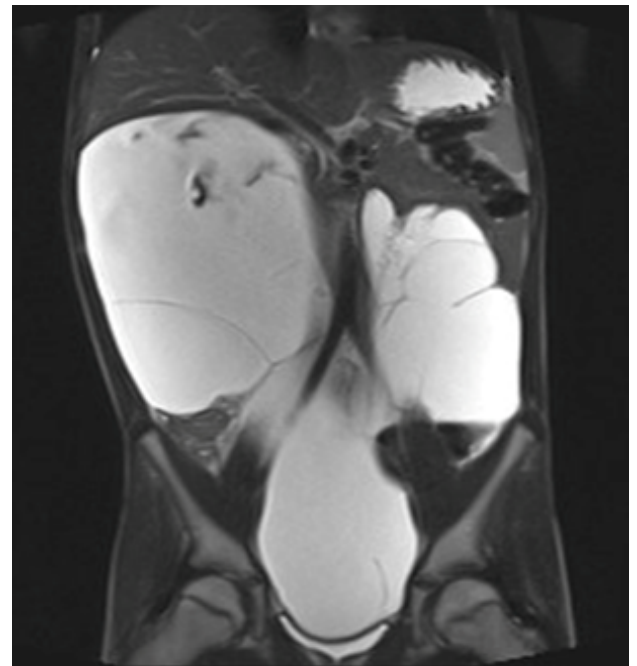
T2 weighted MRI coronal slice showing large multi-septated cystic, gigantic mesenteric lymphatic malformation.
